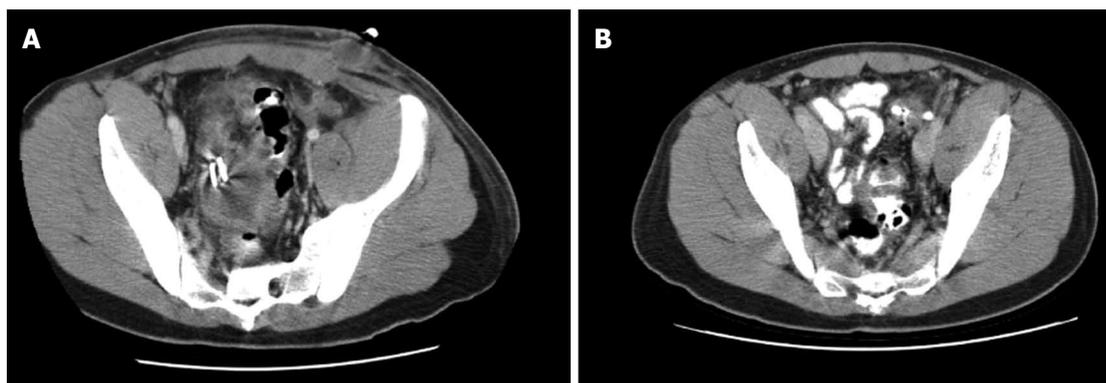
Follow-up computed tomography scans showing initially partial (A) and later complete (B) resolution of pelvic abscess.
